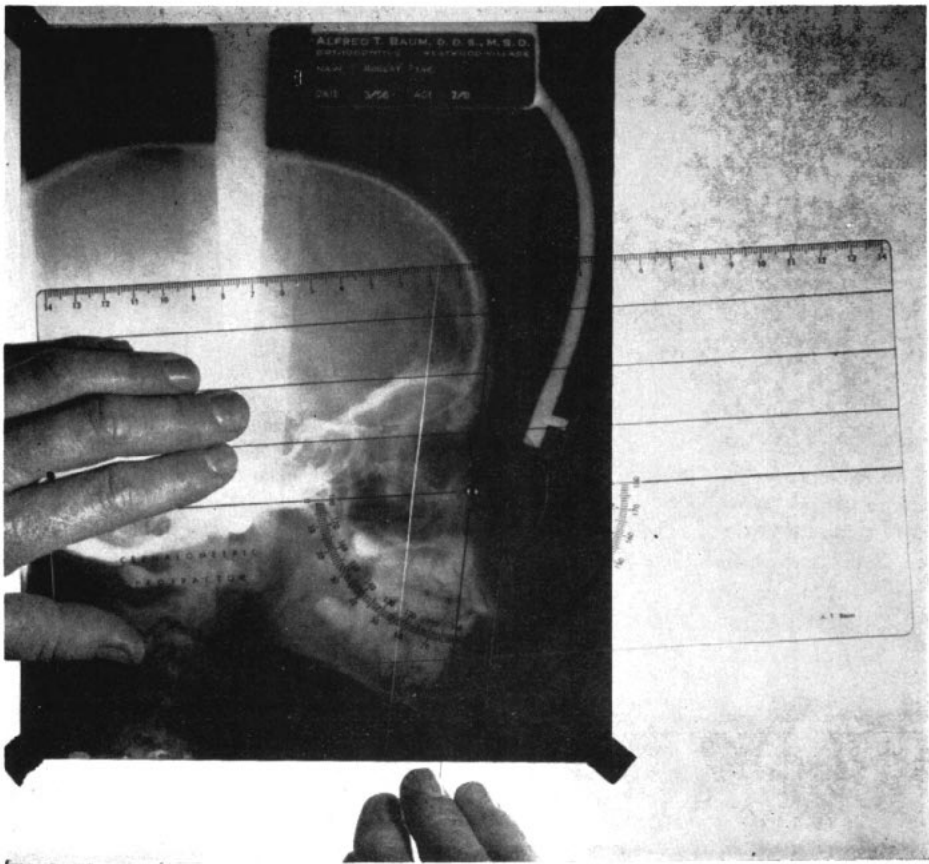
The protractor in use on a lateral x-ray mounted on a light box.
